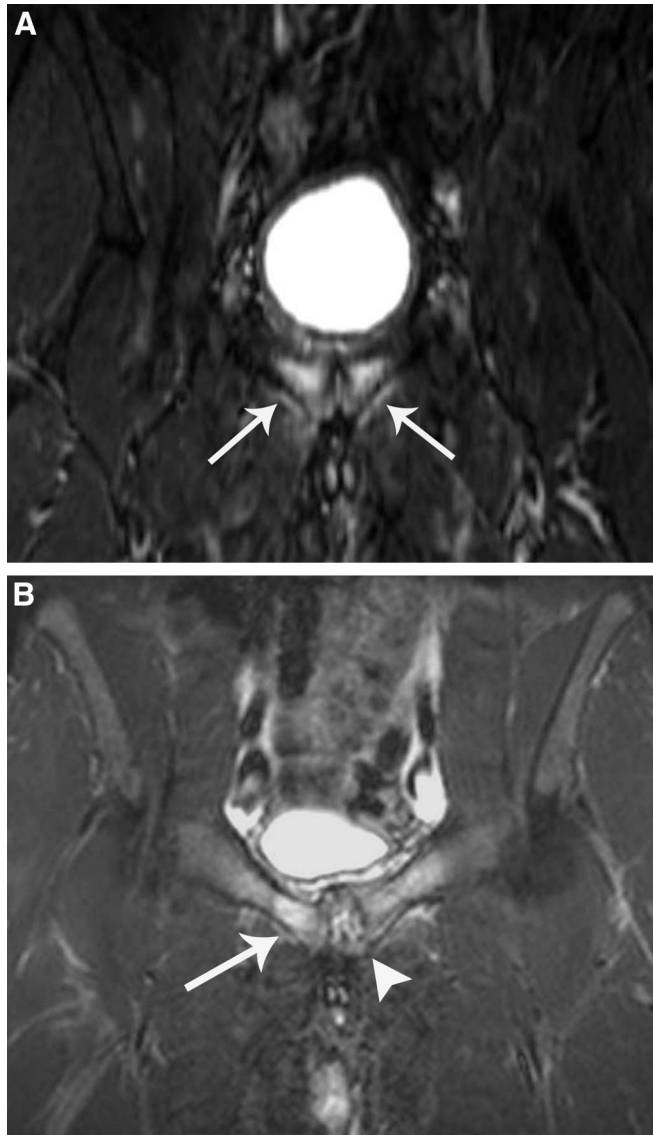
MRI appearance of osteitis pubis: Short tau inversion recovery (STIR) sequence in a coronal plane from a traditional musculoskeletal pelvis protocol (A) shows bright bone marrow edema (arrows) symmetrically across the pubic symphysis indicating an inflammatory process. Poor resolution limits evaluation of soft tissue attachments and osseous cortex. STIR sequence with the higher resolution of an athletic pubalgia protocol (B) shows the bone marrow edema (arrow), plus osseous productive change, and obvious articular erosion (arrowhead).
